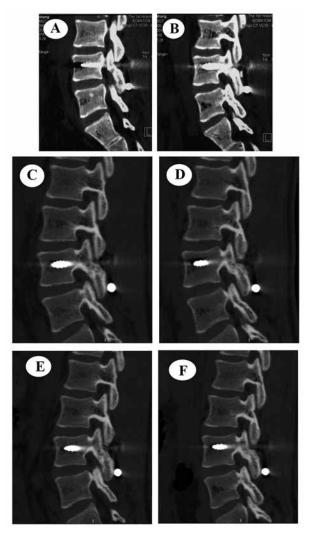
Bone union process of the pars. CT scan indicates that the bone union process began to appear at the bilateral pars 3 months after the operation (A, B). Bone union is exceptionally good after 1 year of operation (C, D). A perfect bone union can be observed at the bilateral pars 2 years after the operation (E, F).
